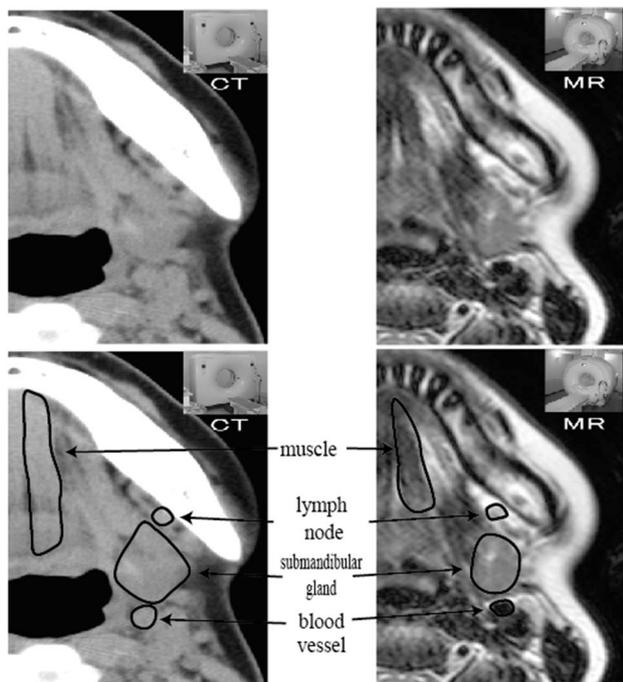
Computed tomography (CT) and magnetic resonance imaging (MRI) of the same slice. MRI has a lower spatial resolution than CT; therefore, tissue boundaries are difficult to ascertain. In contrast, MRI has a high ability to resolve tissues. While CT scans do not indicate density differences among tissues, the differences in density among tissues are clear in MRI scans
